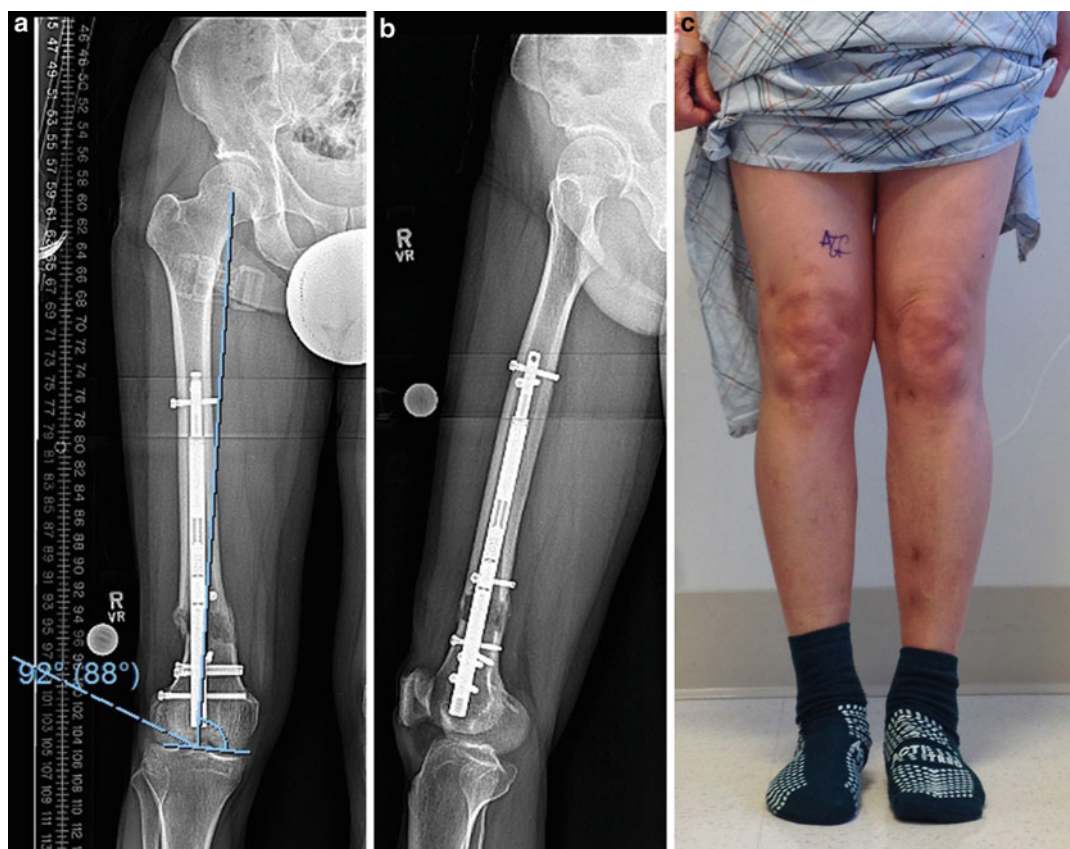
The final AP (a) and lateral (b) radiographs show the desired coronal translation and no lengthening-related secondary deformity. A final clinical photo before IM nail removal shows complete resolution of the varus deformity (c)
